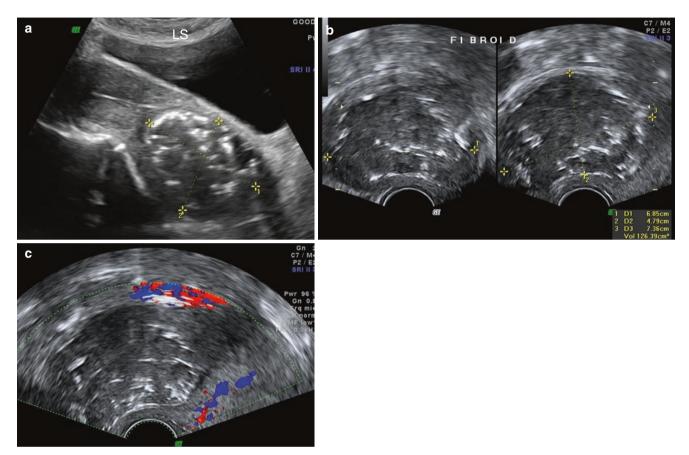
Fibroid seen on the third day after embolisation. The patient presented with acute abdominal pain. On ultrasound, the fibroid was found to be tender. (a) LS of a uterus showing a posterior wall, lower corpus and upper cervical fibroid. (b) Fibroid is measured. It showed a 10% increase in size from the previous scan done a month earlier. Scattered bright linear echoes suggestive of air are seen within the fibroid which were not seen in the earlier scan done a month ago. This is a known feature following embolisation. (c) No flow was seen on Doppler in the fibroid, which is expected following embolisation
